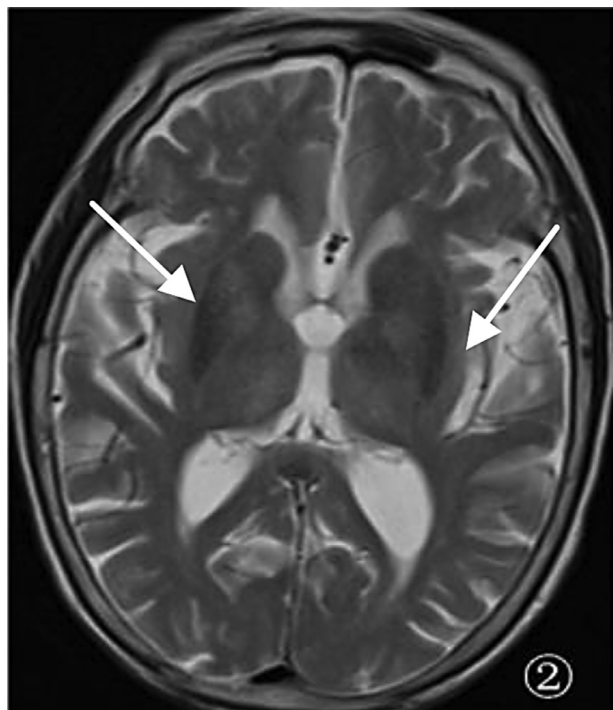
T2WI of transverse section: Symmetry low-signal intensity on T1-weighted of bilateral basal ganglia.
